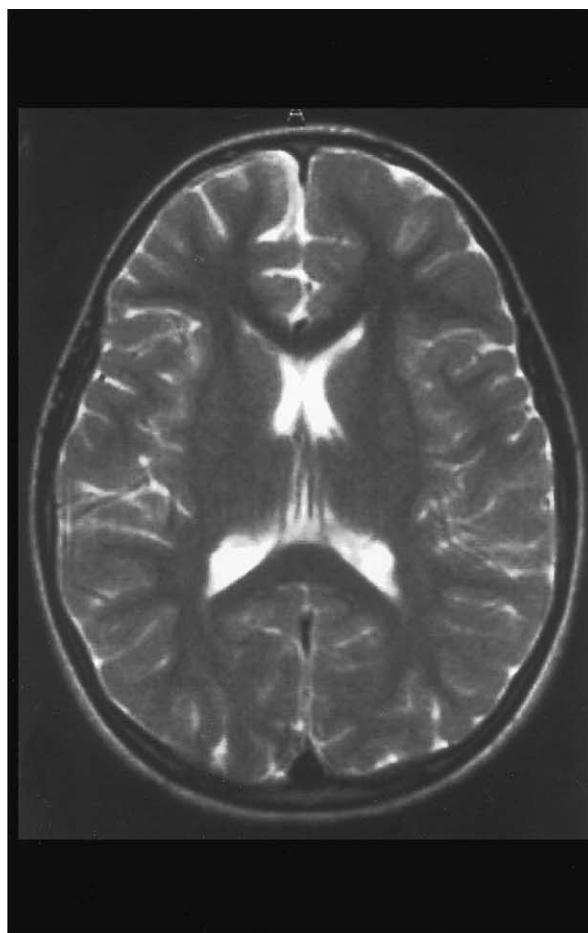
(a) Axial T2-weighted MRI spin echo sequence showing mild enlargement of subarachnoid spaces of the right frontal lobe. (b) Coronal proton density-weighted MRI spin echo sequence showing normal cerebellum.
